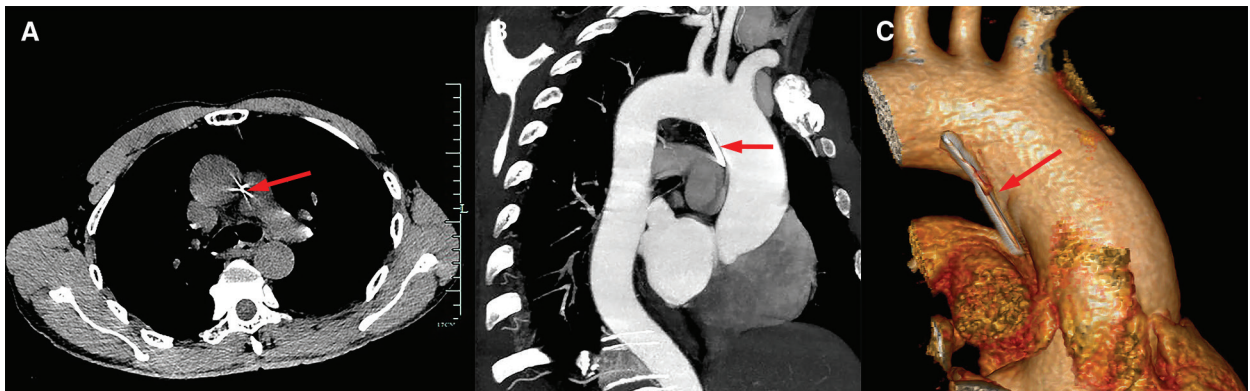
(A) The needle (arrow) is presented as a starlight-like spot of high density in the CT image (B) and the three-dimensional reconstruction (C) shows a needle (arrow) obliquely penetrating through the esophagus into the adhesion area between the ascending aorta and the pulmonary artery, adjacent to the aortic arch.
